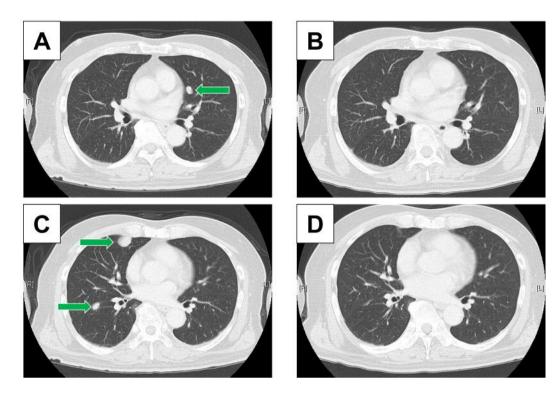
Representative images before (A, C) and after (B, D) carboplatin/docetaxel treatment in a patient with recurrent/metastatic, castration-resistant salivary duct carcinoma. Post-treatment computed tomography scans revealed a complete response of all pulmonary metastatic lesions (green arrows).
